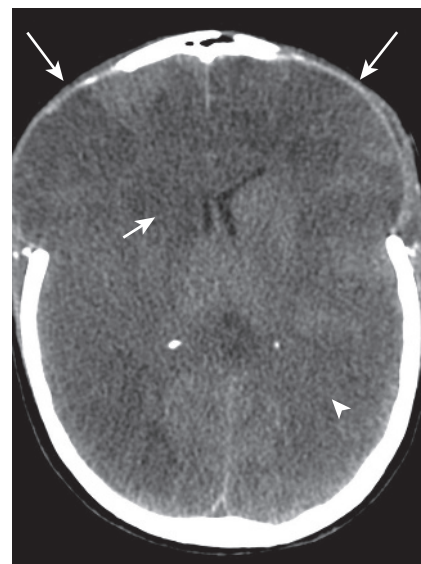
Axial non-contrast computed tomography scan of the brain in a trauma patient after bi-frontal craniectomy (*long arrows*) to manage widespread cerebral oedema (*arrowhead*). Multiple areas of infarction are present in the frontal lobes bilaterally and in the right basal ganglia (*short arrow*). A catheter angiogram subsequently demonstrated multiple traumatic intracranial arterial dissections as causative.
